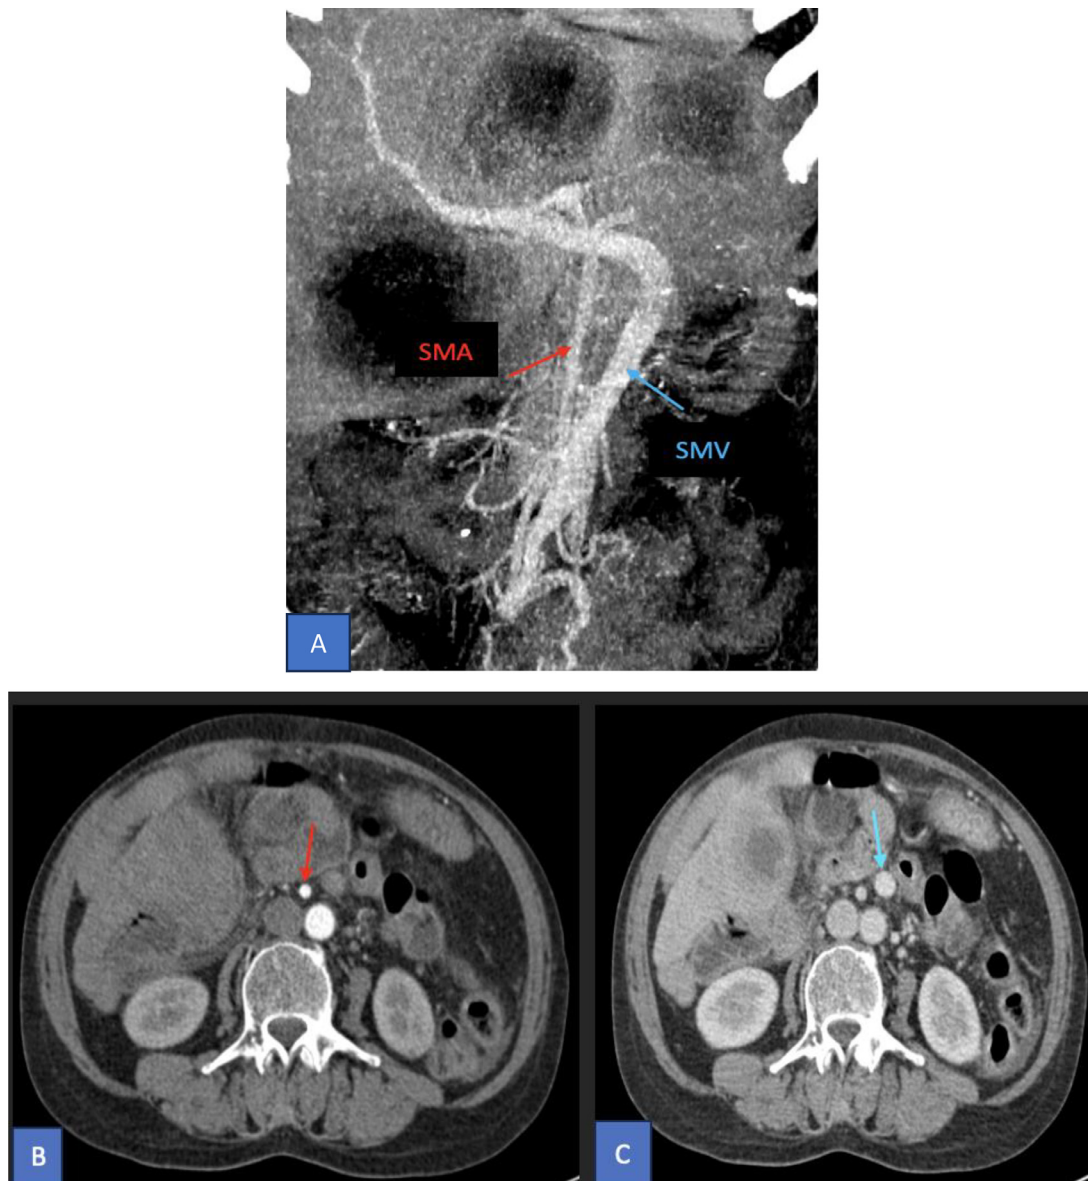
Coronal MIP CT (A) showing an inverted orientation of the superior mesenteric artery (SMA) and superior mesenteric vein (SMV). In the axial contrast-enhanced CT, the arterial phase (B) reveals the superior mesenteric artery positioned on the right (red arrow), while the portal phase (C) shows the superior mesenteric vein on the left (blue arrow).
